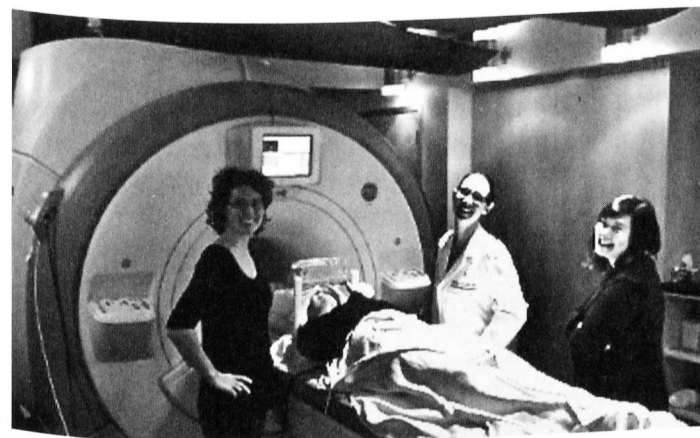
A student enters the MRI scanner to read a chapter of *Persuasion* in our pilot. Participants read a digital version of the text through a mirror above their eyes, which reflects the text on a screen at the back of the scanner.
